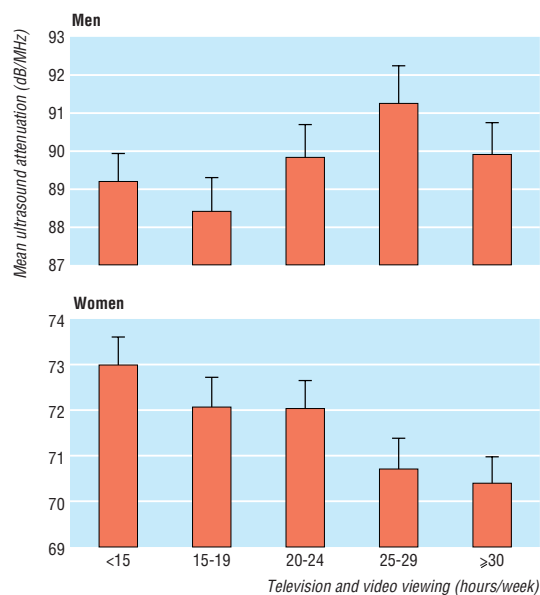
Mean (SE) ultrasound attenuation according to hours of television and video viewing adjusted for age, weight, smoking history, and ultrasound machine for men and women plus menopausal status and hormone replacement therapy for women
